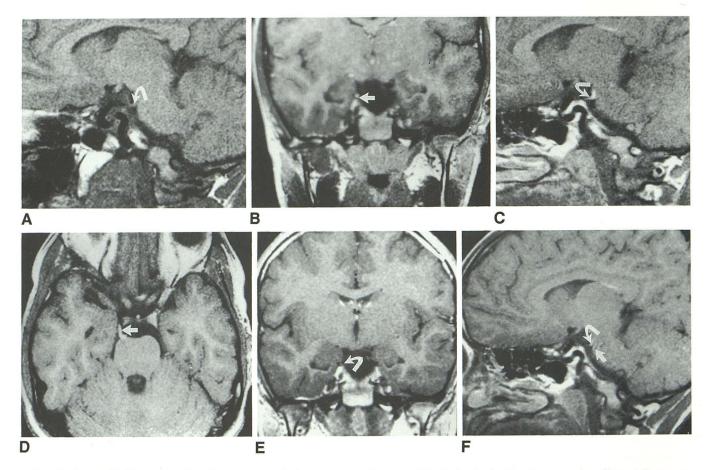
Patient 7; 7-year-old girl with severe headache, nausea, vomiting, and a right third cranial nerve palsy. Clinical diagnosis: ophthalmoplegic migraine. Precontrast parasaggital (A) T1-weighted image through the right third nerve (*curved arrow*). Postcontrast coronal (B), parasagittal (C), and axial (D) T1-weighted (600/20) images demonstrate enhancement of the third cranial nerve (*arrows*) and of the pia in the interpeduncular cistern. Follow-up coronal (E) 3 weeks later demonstrates resolution of the enhancement of the anterior aspect of the third cranial nerve (*curved arrow*); minimal residual enhancement of the posterior aspect of the nerve and pia in the interpeduncular cistern is still present (*curved arrow*) on the parasagittal image (F). A phase encoding artifact is seen just below the third cranial nerve (*straight arrow*). The patient's symptoms resolved spontaneously.
